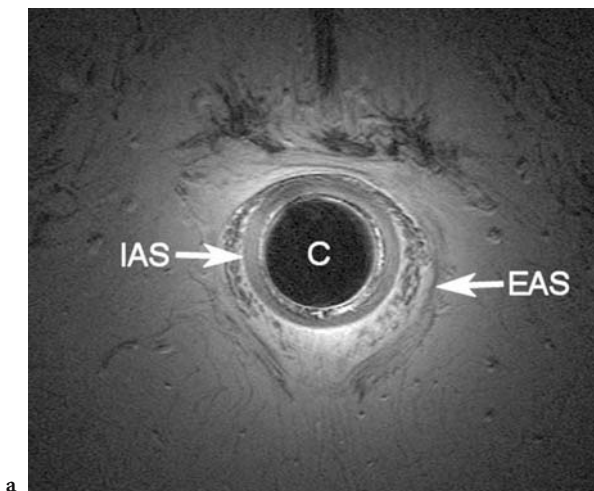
Axial endoanal T2- weighted fast spin-echo MR image showing mild thinning of the external anal sphincter (EAS) muscle and diffuse replacement of EAS muscle by fat in a 68-year-old woman with fecal incontinence and diabetic mellitus. IAS internal anal sphincter, C endoanal coil
